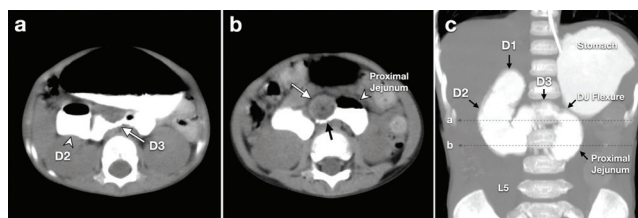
Supplementary plain CT abdomen in axial view (a) at the level of D3, (b) at the level of proximal jejunum (b) and (c) coronal view with maximum intensity projection (MIP). (a) The D2 (arrowhead) and D3 (white arrow) are located at the retroperitoneum. (b) Whirlpool sign (white arrow) with 'beaking' appearance of the bowel (black arrow) at proximal jejunum (arrowhead). (c) Dotted lines show the level of axial view in (a) and (b), respectively. The first part of the duodenum (D1), D2, D3, DJ flexure and proximal jejunum are identified and labelled with black arrows.
